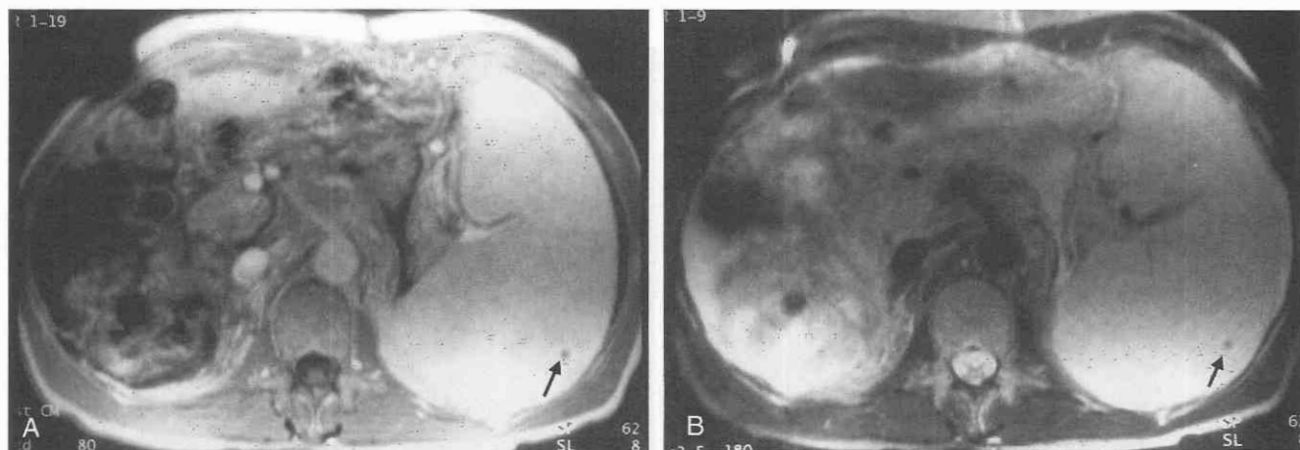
Portal hypertension, splenomegaly, and gamma-gandy body on MR images. A, T1-weighted image reveals massive splenomegaly. A gamma-gandy body is noted as low-signal, nonenhancing focus (arrow). B, T2-weighted image shows that the gamma-gandy body is low in signal (arrow).
